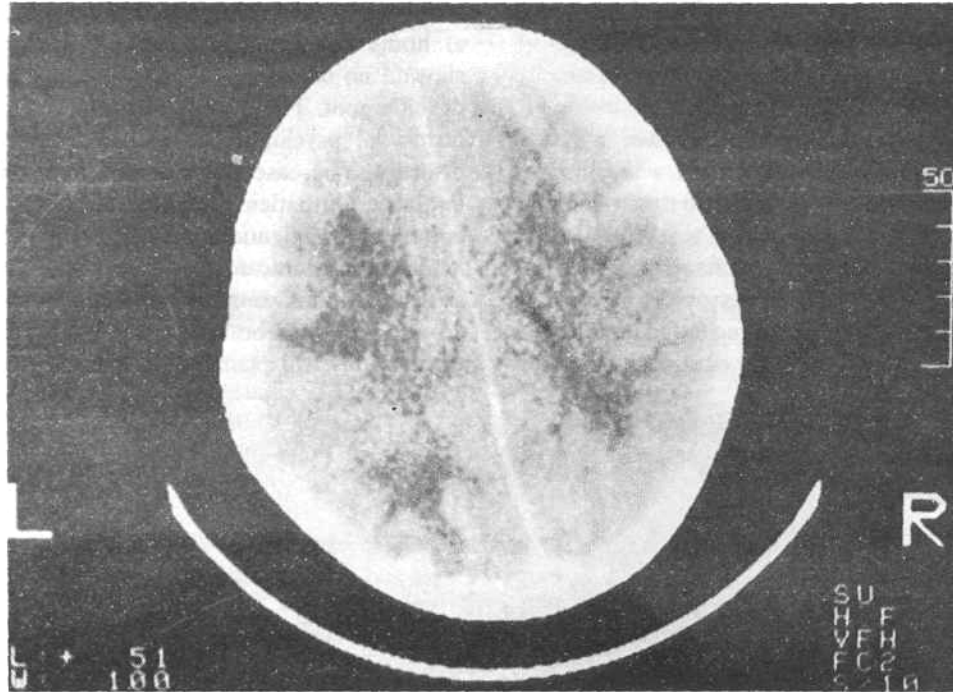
CT Scan showing hypodense rounded lesions of cerebral cysticercosis.
